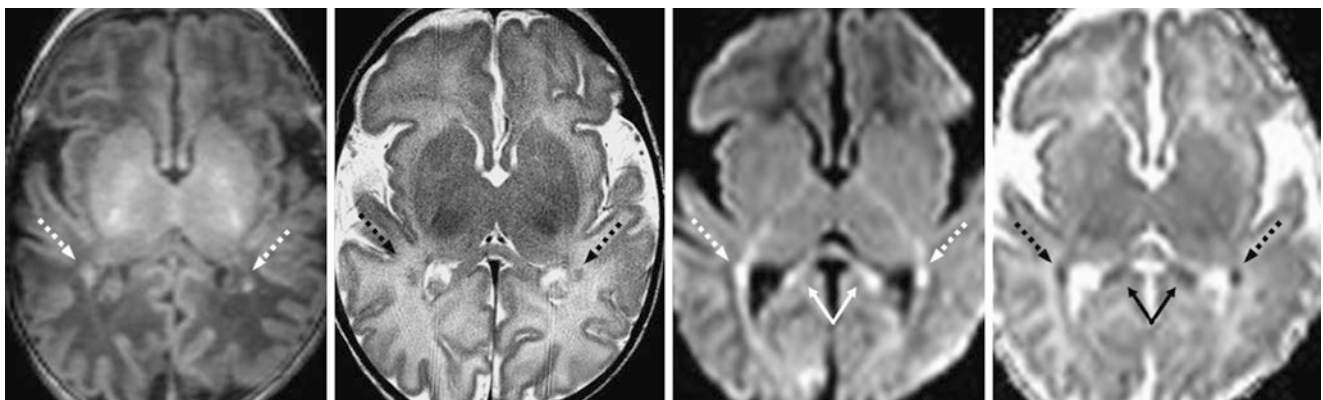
Comparison case of hypoxic white matter injury. After cardiac arrest, a 9-day-old term infant had a 3T MRI that showed non-hemorrhagic periaxial foci (*dotted arrows*) on GE T1WI (*left*) and SE
